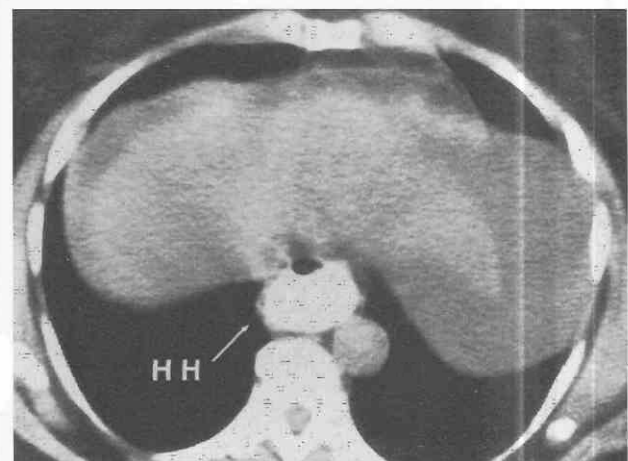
Hiatal hernia. CT shows herniation of a portion of the stomach (HH) through the esophageal hiatus.
